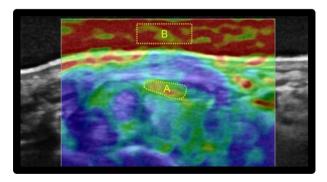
Transverse images of a 57-year-old female. (a) Conventional Bmode ultrasound image shows sonoelastographic. The color represents the elasticity of the tissue. The strain ratio of the AC (b) to the MN (a) was 2.9. AC, acoustic coupler; MN, median nerve.
